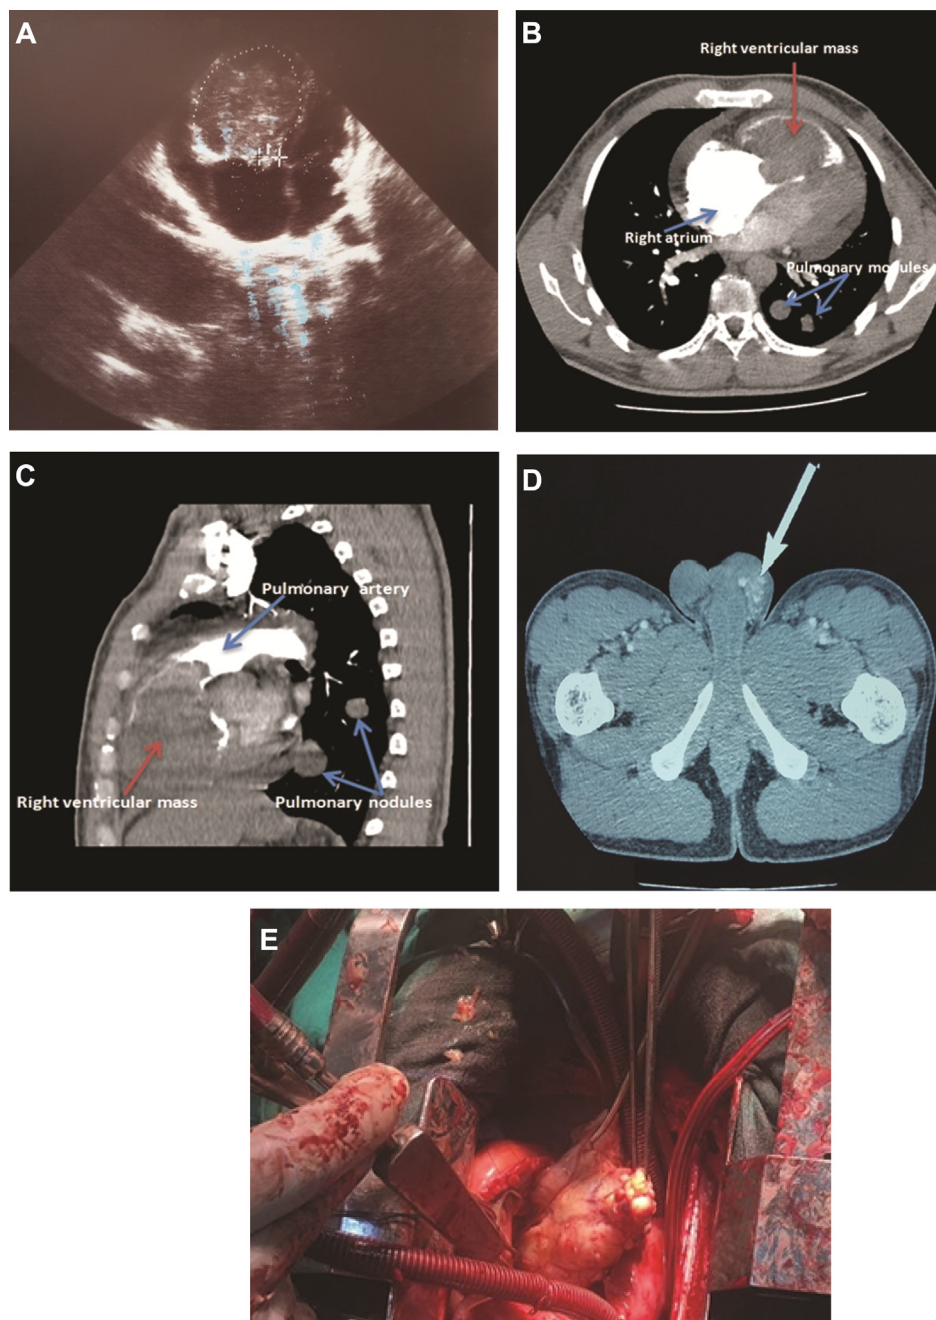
(A) Transthoracic echocardiography revealing a huge right ventricular mass occupying almost all the ventricular volume. (B and C) Chest computed tomography showing the presence of the solid mass that extending to the root of pulmonary artery with multiple pulmonary nodules. (D) Testis computed tomography showing a heterogeneous aspect with multiple classifications of left testicle. (E) Surgical view of the right ventricular mass.
